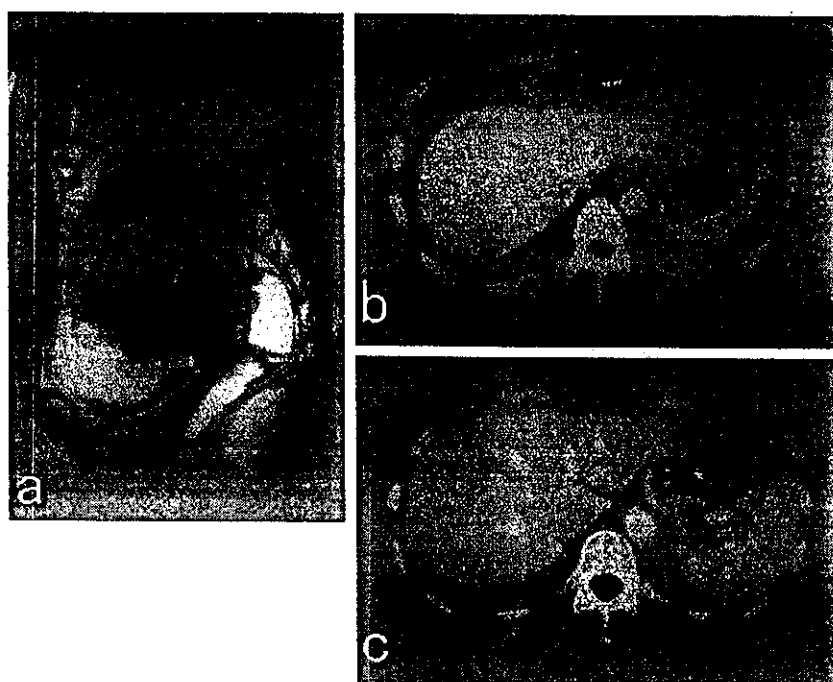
Findings of CT and MRI in case 2. a. Large amount of ascites and pelvic mass are recognized (before initial surgery) (Sagittal). b. Low density area in right lobe of liver is seen (before initial surgery) (Axial). c. The low density area in liver shrinks after 6 cycles of CAP (Axial).
